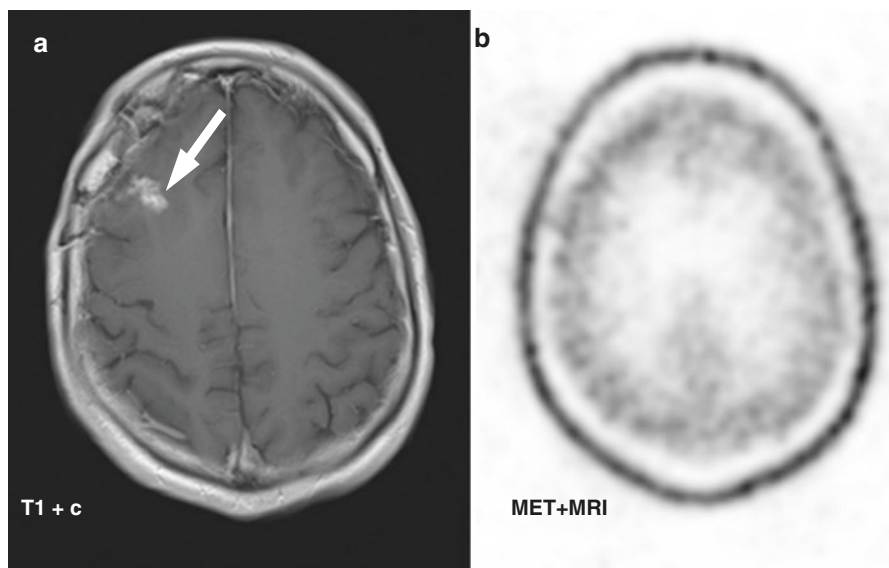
Example of MET PET follow-up in a patient with a brain metastasis. Case of a 54-year-old male with right frontal solitary brain metastasis from a fibrosarcoma. The patient was treated with surgical resection and stereotactic radiosurgery. After treatment, follow-up gadolinium-enhanced MRI showed a new contrast-enhancing lesion (white arrow). MET PET was performed which did not demonstrate increased tracer uptake at the lesion site. The contrast enhancement was in this case shown to be due to treatment-induced changes
